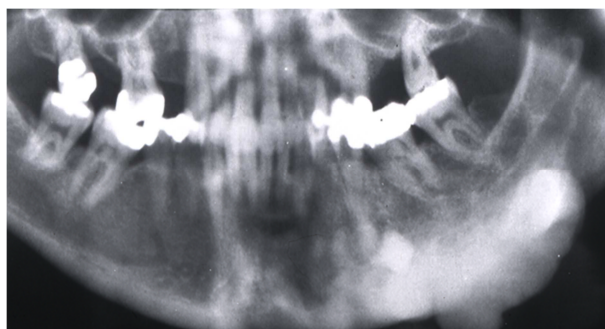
Radiograph of the jaw bone demonstrates a well-circumscribed, homogeneously dense lesion.
